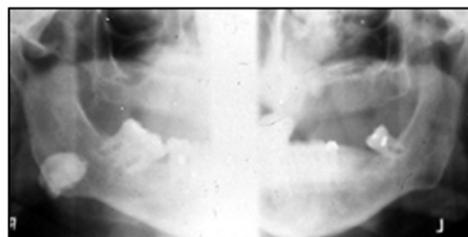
Sialolith Radiograph
